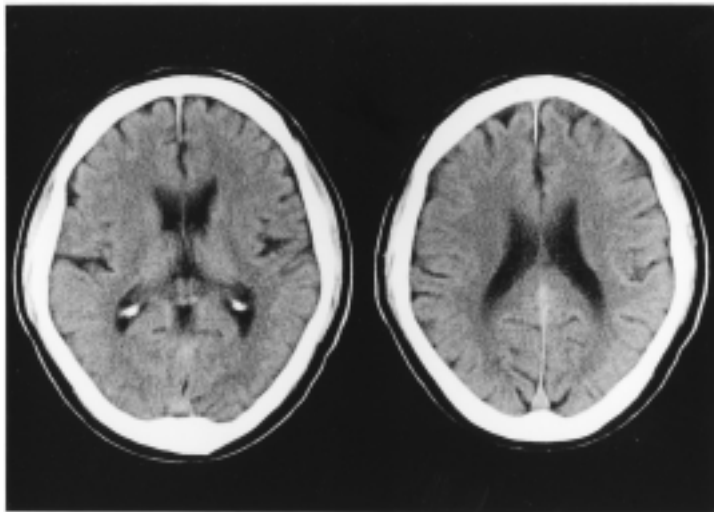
Cranial x-ray CT examination. Plain CT scan performed 6 days after the attack shows no particular abnormal findings.
